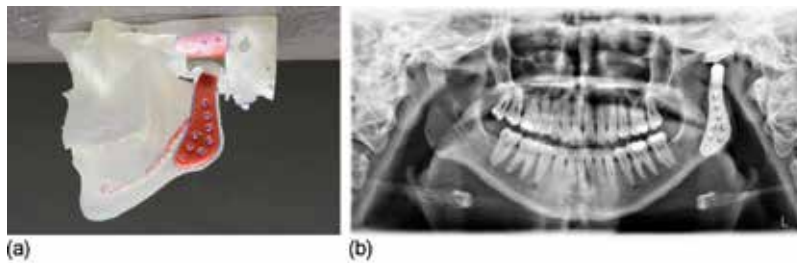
The total joint reconstruction combines the replacement of the fossa and the condyle at the same time; (a) production stage of custom-made TMJ prosthesis which is made individually according to the patient's CT-based stereolithographic model, (b) postoperative OPG of a patient with custom-made TMJ prosthesis.
